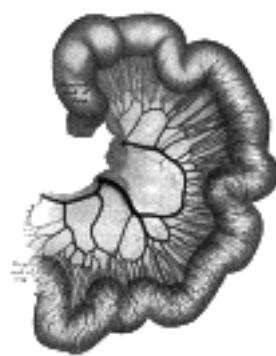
Loop of small intestine showing distribution of intestinal arteries. (From a preparation by Mr. Hamilton Drummond.) The vessels were injected while the gut was *in situ*, the gut was then removed, and an x-ray photograph taken. (See enlarged image)
